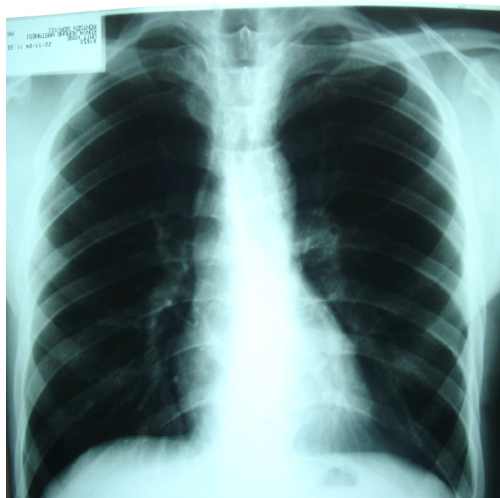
Radiograph after 12 months treatment
